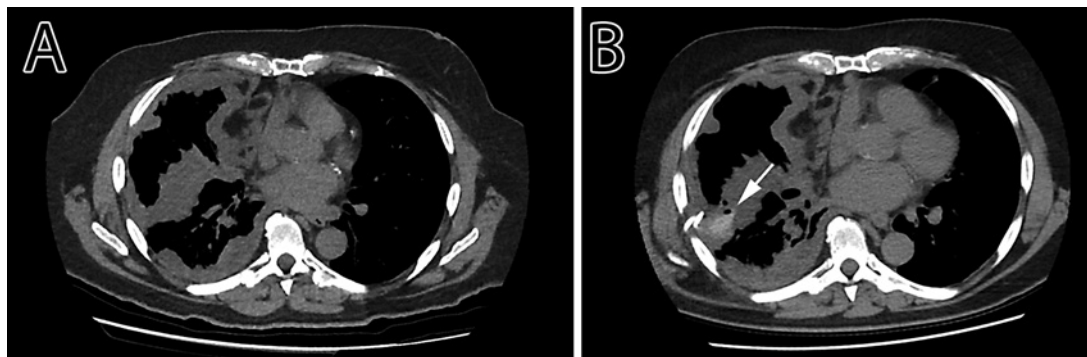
Pre-treatment (A) axial computed tomography section demonstrating pleural recurrence from PMP disease in a 68-year-old male. B Day 3 post-BromAc® treatment progress scan with contrast injected through self-retaining drain. The arrow indicates only regional diffusion of contrast around the drain site.
